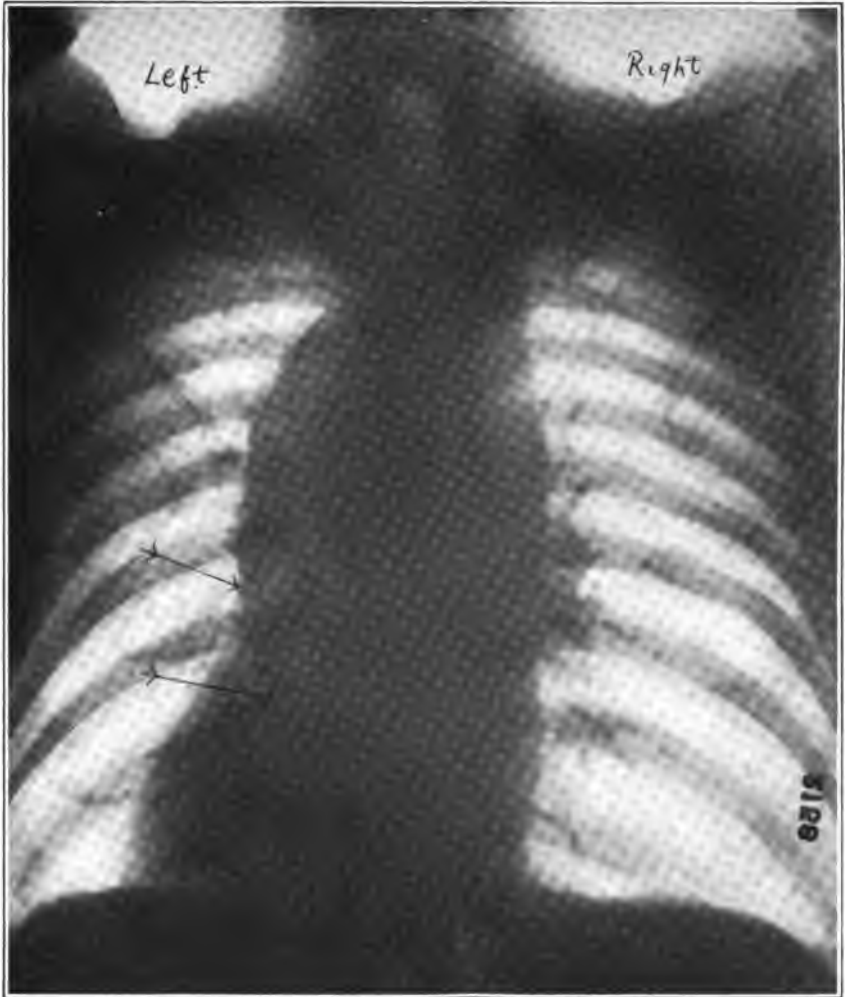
Photograph from X-ray plate, showing aneurismal dilation of the descending thoracic aorta.
